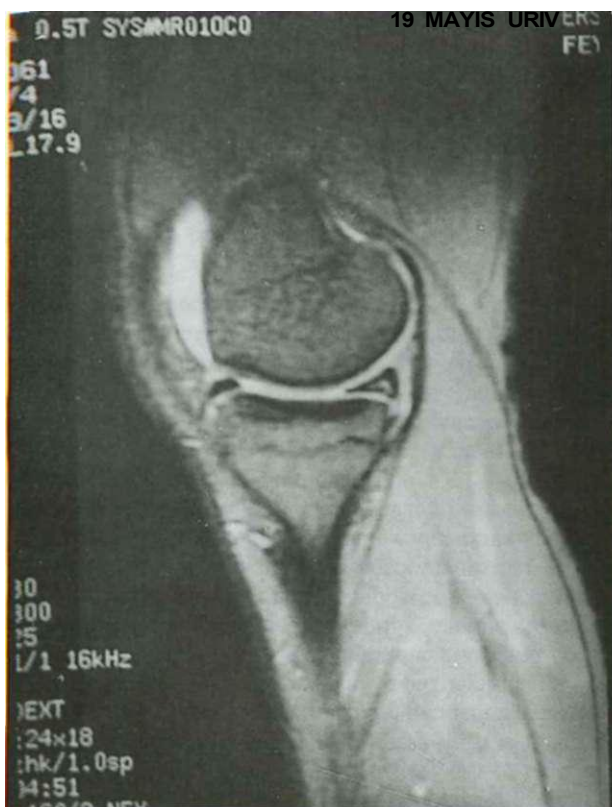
Grade-1 degeneration is seen at posterior horn of the medial meniscus on T2-weighted sagittal image.
